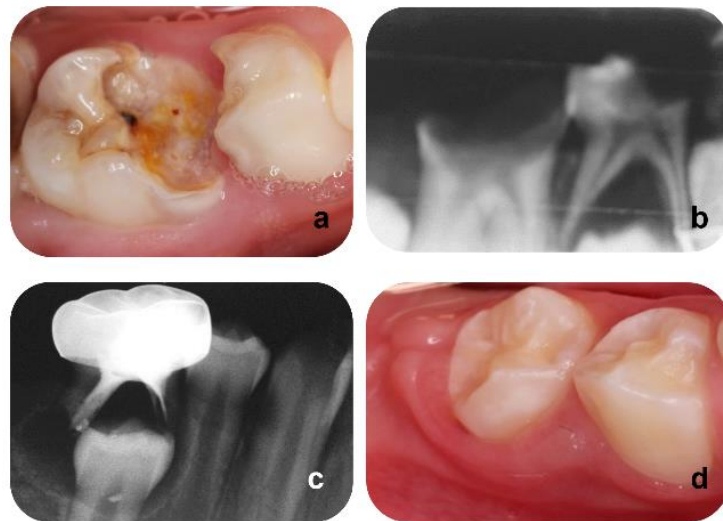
Initial clinical and radiographical evaluation- a and b. At the 9 month-evaluation, an oval radiolucent image involving the tooth was observed- c. Succedaneous tooth erupted presented no alterations - d. Pediatric Dentistry Clinic/ PI- Brazil 2019.
